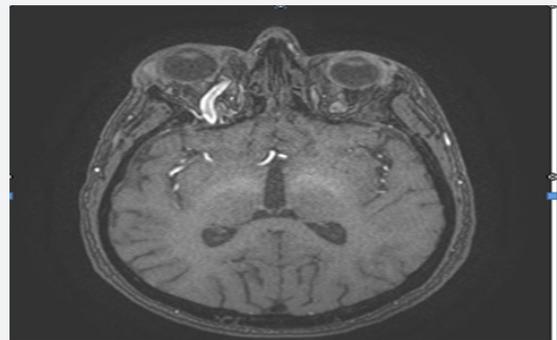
MRI: VOS dilated.
